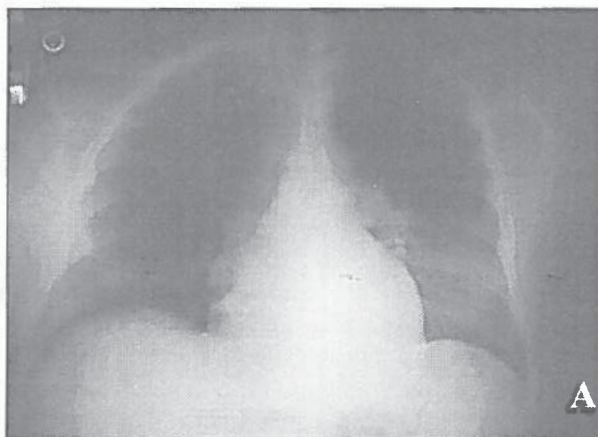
Chest radiograph upon admission, which shows a reticular infiltrate in the lower lobe of the left lung.
